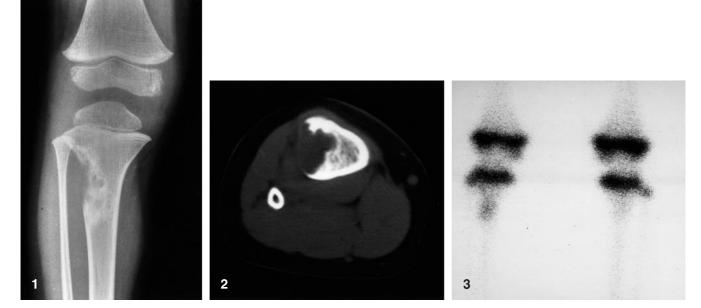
Anteroposterior radiograph shows an eccentric, lytic, metaphyseal lesion with cortical destruction but no periosteal reaction. The lesion has a lobulated margin with a thin rim of sclerosis
